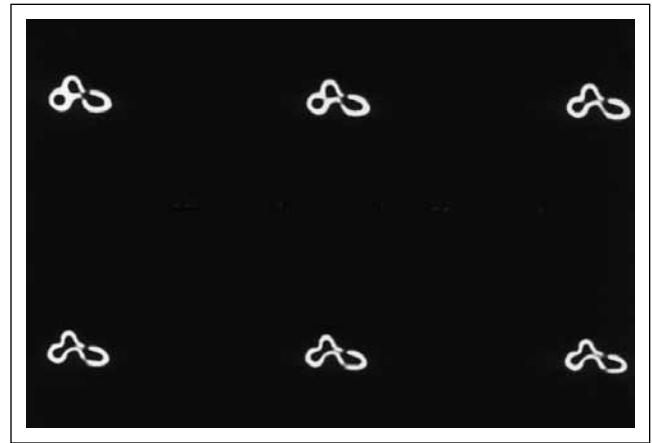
CT images of the root of case no. 2. At the mid-root level a total joining of the root canals of distal and labial teeth can progressively seen. A tri-lobulated single root and tri-lobulated single root canal can be seen.
